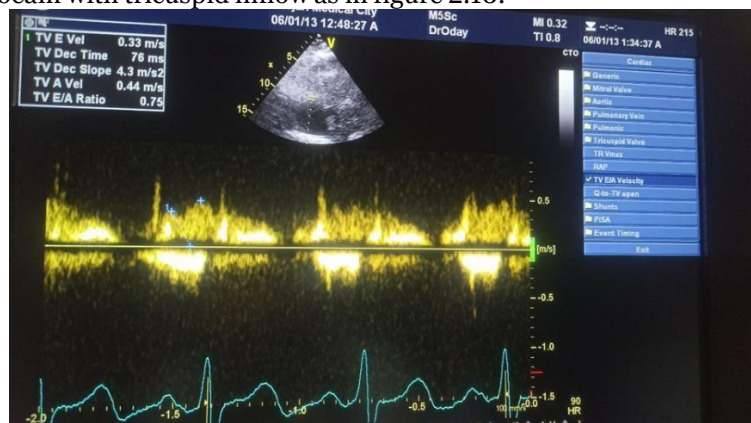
PW, Doppler measured inflow of tricuspid wave (E/A ratio)
